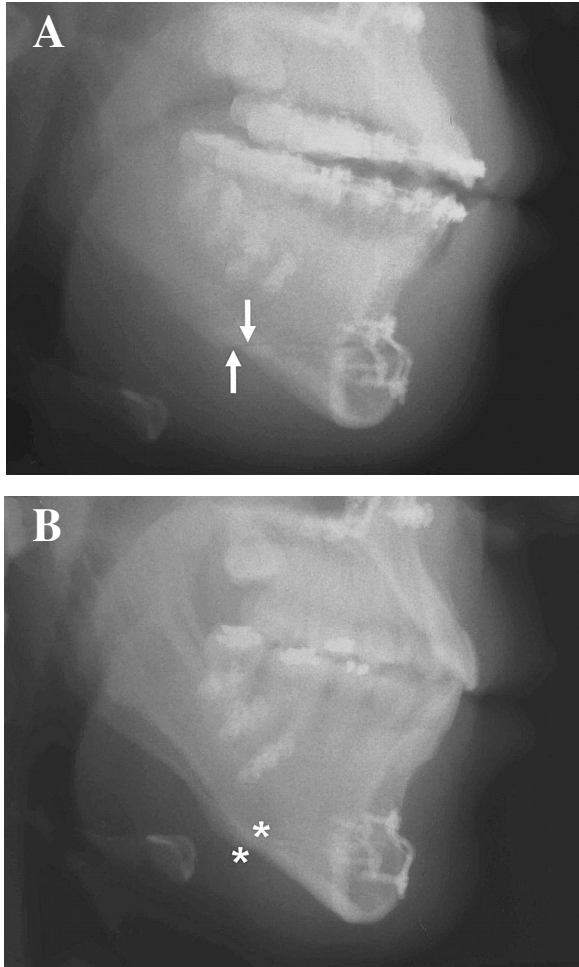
Radiographic demonstration of bone remodeling along the border of the mandibular corpus. (A) The arrows show the mandibular split area 1 week after surgery. (B) The asterisks show healing of the bone along the split area 1 year after surgery.
